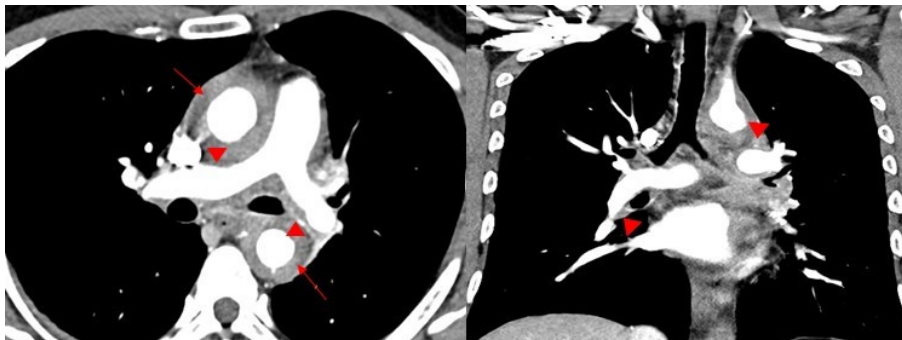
Chest CT shows wall thickening of ascending, descending aorta(arrows) and both pulmonary arteries(arrow tips).
